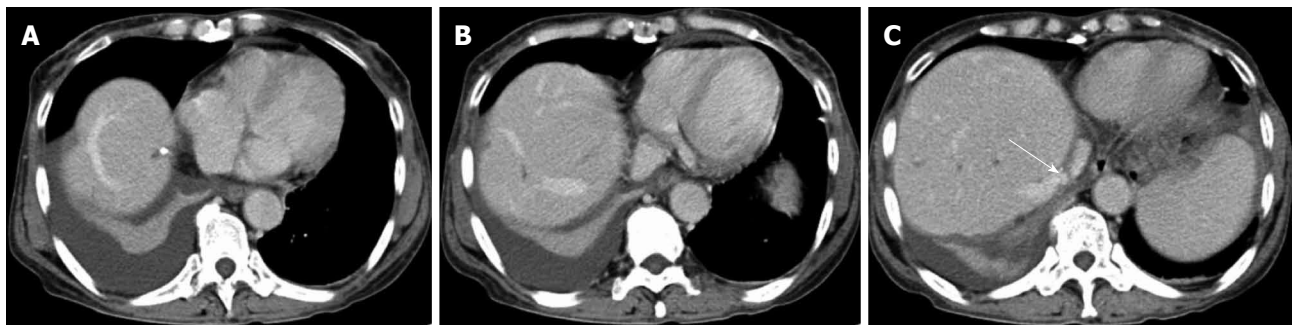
Postoperative computed tomography scan. A, B: Demonstrated good right hepatic vein tract; C: The inter-positioned graft using an allogeneic iliac vein (arrow).
